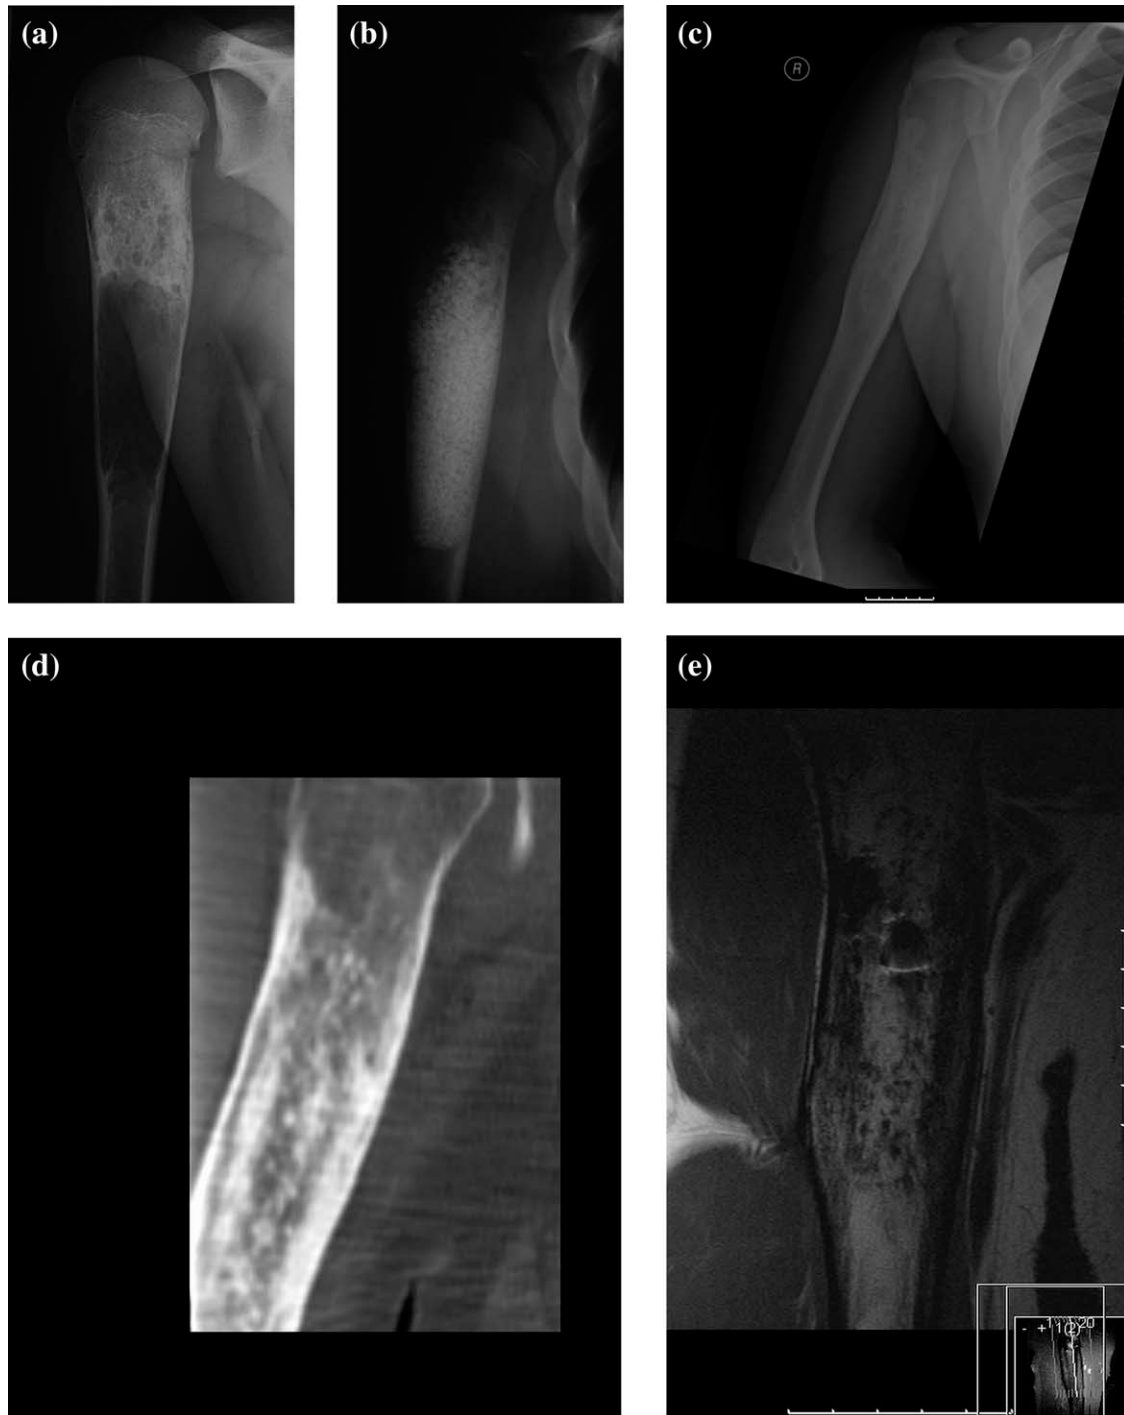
Aneurysmal bone cyst in the humerus treated with BG, (a) preoperative X-ray, (b) postoperative X-ray showing cavity filled with BG granules, (c) long-term follow-up X-ray showing the treated cavity with a dense appearance, (d) long-term follow-up coronal CT reformat of the treated cavity showing remnants of glass granules in the bone, (e) long-term follow-up coronal T1 MRI of the treated cavity showing a mainly fatty bone marrow with remnants of glass granules.
